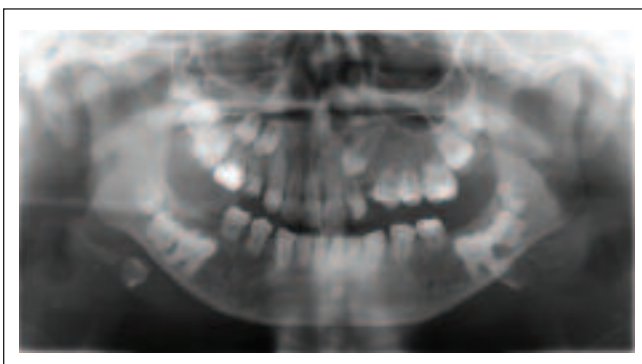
Panoramic radiography. Osteopenia, widened root canals, shortened roots with open apices and impacted teeth can be seen.
